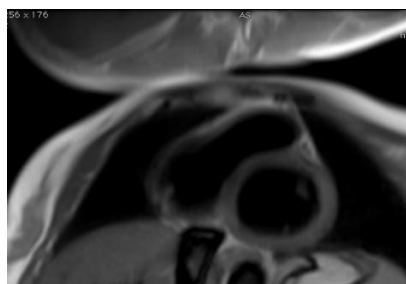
Short-axis T2-weighted sequence: No hyper intensity observed, indicating the absence of edema.
